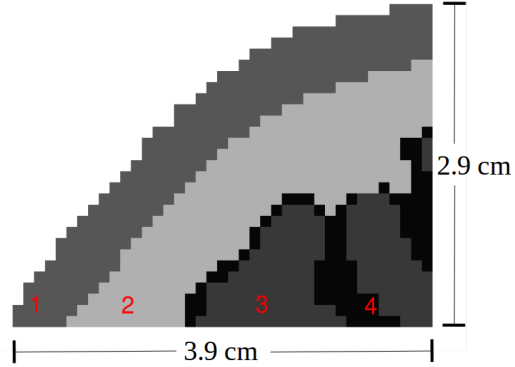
Image from MRI measurements of a human head. Material 1 is the skull, material 2 the cerebrospinal fluid (CSF) and material 3 and 4 are grey/white matter.
